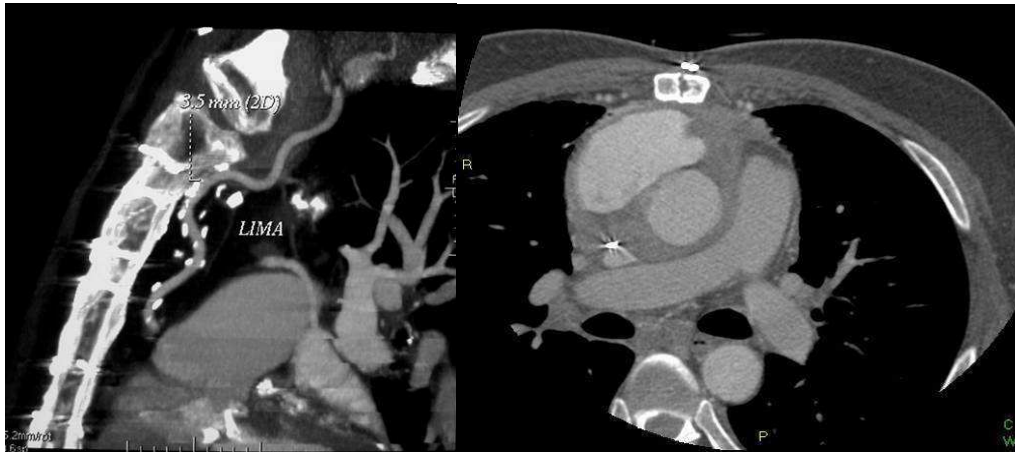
preoperative CT scan showing patent LIMA graft (A) and aortic pseudoaneurysm in contact with sternum (B).
